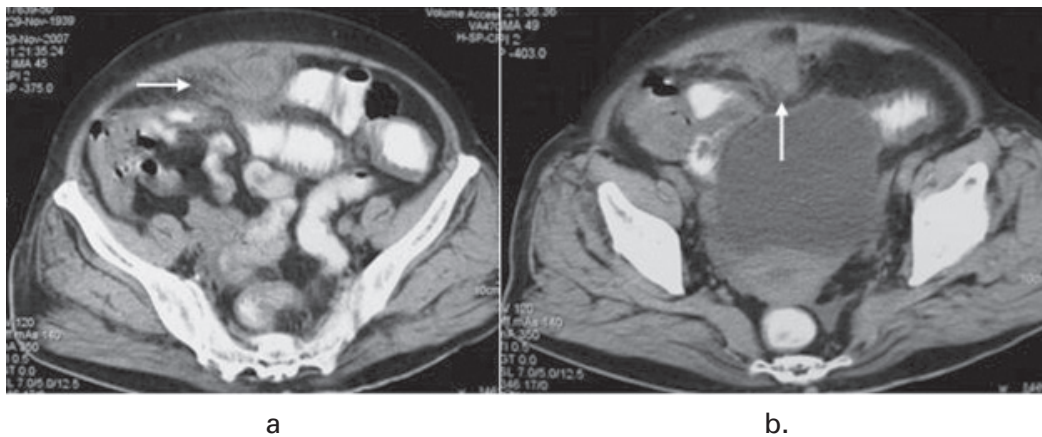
Axial non-contrasted CT scan. (a) An irregular fluid-filled structure in the midline of the anterior peritoneal cavity with adjacent fat reticulation. (b) Soft tissue extension to the dome of urinary bladder.
